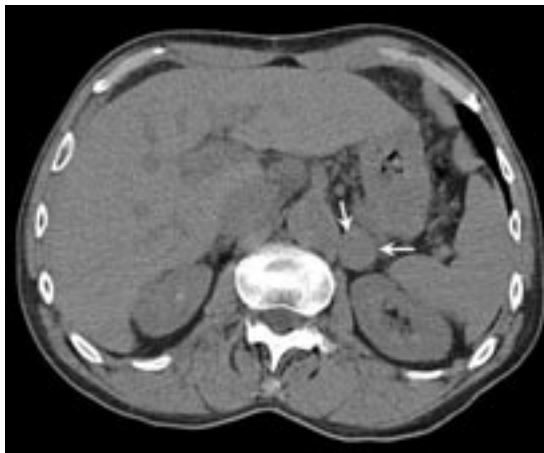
Noncontrast CT image of a left adrenal mass measuring 2.2 x 1.3 cm. The mass has an attenuation value of 40 HU, indicating low fat content; therefore, contrast enhancement washout should be measured.
